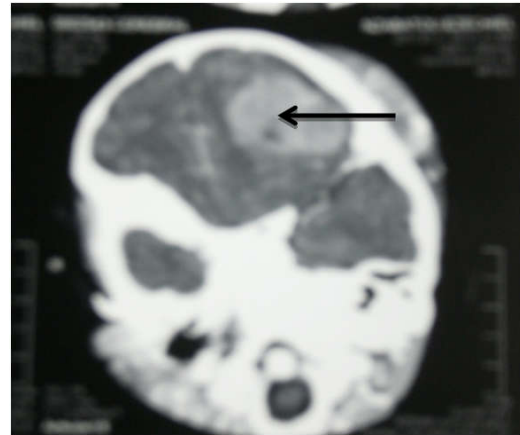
Cerebral computed tomography with brain tumor
